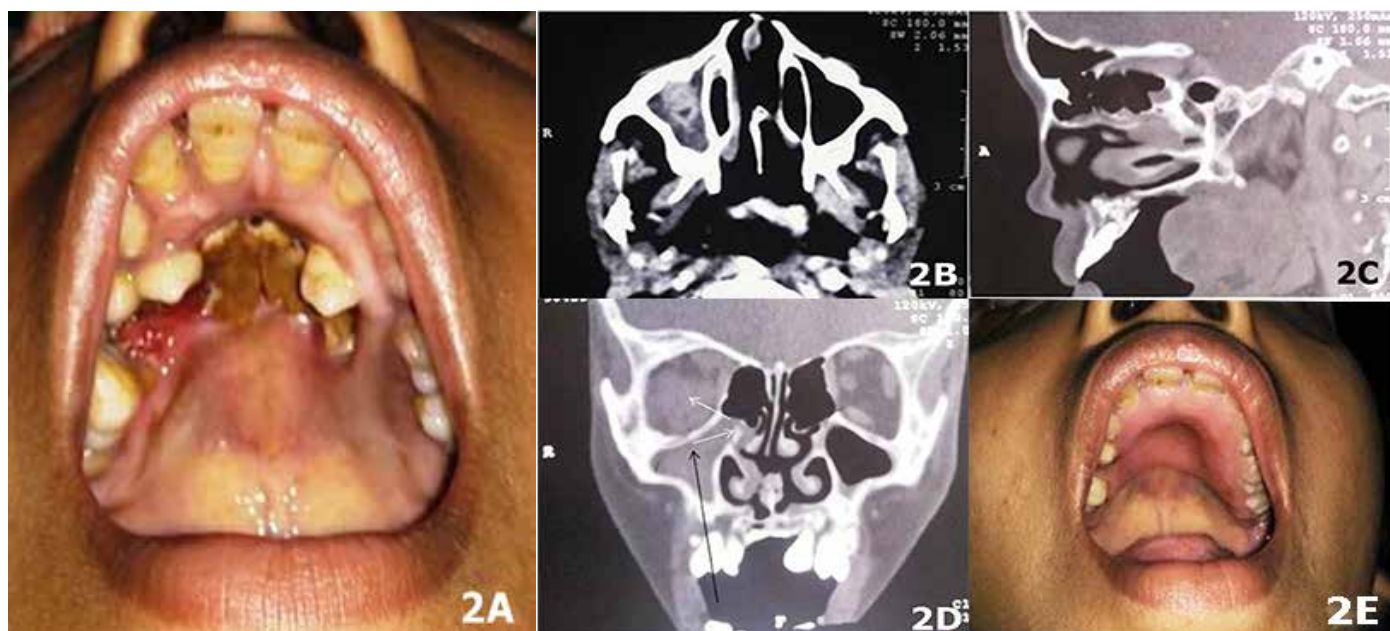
A painless hard palate fistula (Fig.2A) was observed in this patient at 17 years of age. A computed tomography scan demonstrated a soft tissue with hyper-densities within it, in the right maxillary sinus (Fig.2B) along-with a defect in the hard palate communicating with the nasal and oral cavities (Fig.2C). The infection possibly traversed from the oral cavity through the palatal fistula to the nasal cavity and eventually into the orbit (Fig.2D). She underwent palatal reconstruction (Fig. 2E) for the fistula.
